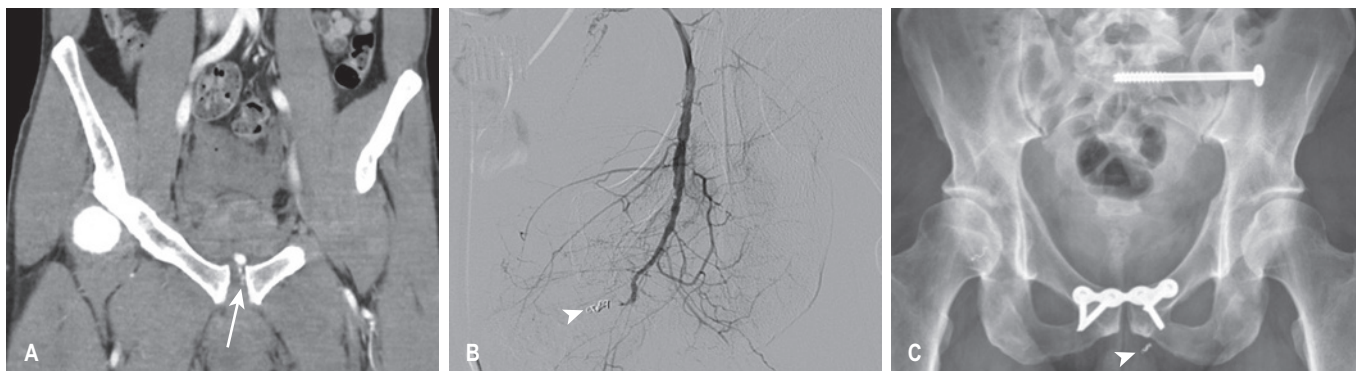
(A) Coronal computed tomography demonstrating contrast extravasation, indicative of active bleeding adjacent to the pubic symphysis and complicating pubic symphysis diastasis (long arrow). (B) Invasive angiogram with catheterization of the left internal iliac artery and deployed micro-coils in a pelvic branch (arrowhead). (C) Radiograph following internal fixation of the pubic symphysis and left sacroiliac joint, showing embolic coil material (arrowhead).
